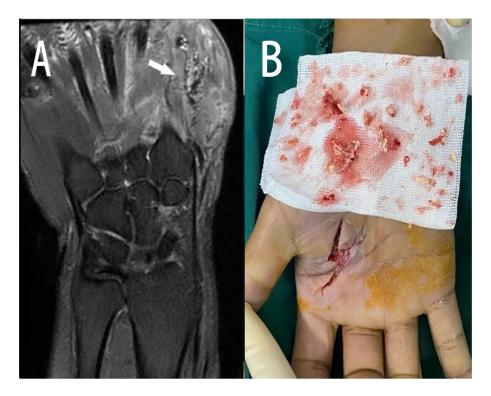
Preoperative MRI images and intraoperative pictures. (A) MRI presented long T2 signals at the basal part of the first metacarpal bone (arrow), with high local median nerve signals. (B) Right-hand debridement surgery, where the polyure than materials were removed along with necrotic tissue.
